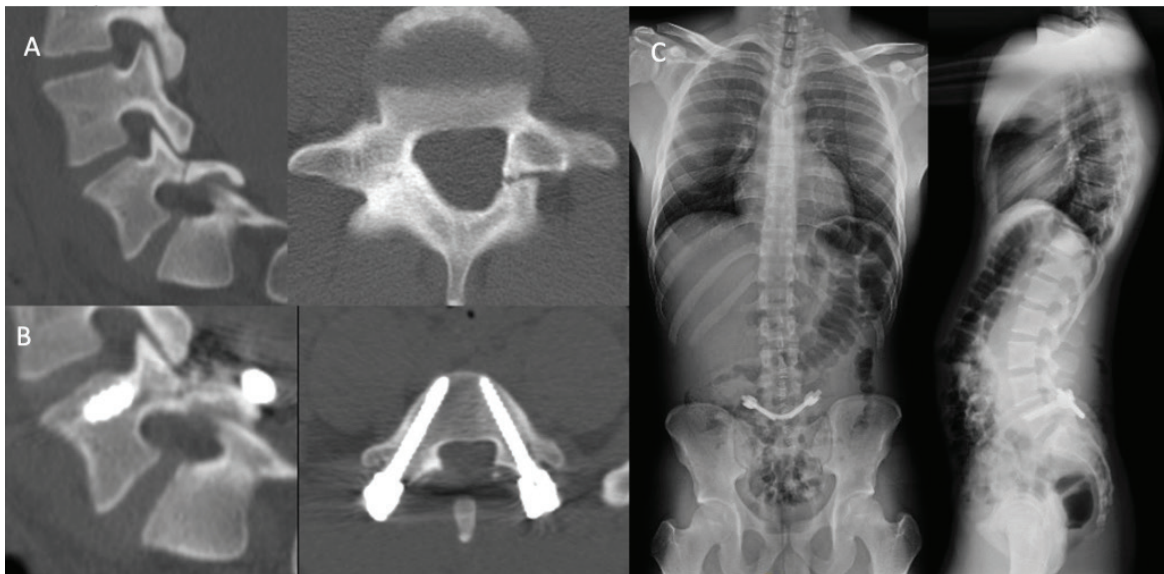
(A) Preoperative CT image of pars defect in one of the patients (B) CT image of complete fusion (C) postoperative radiographs
